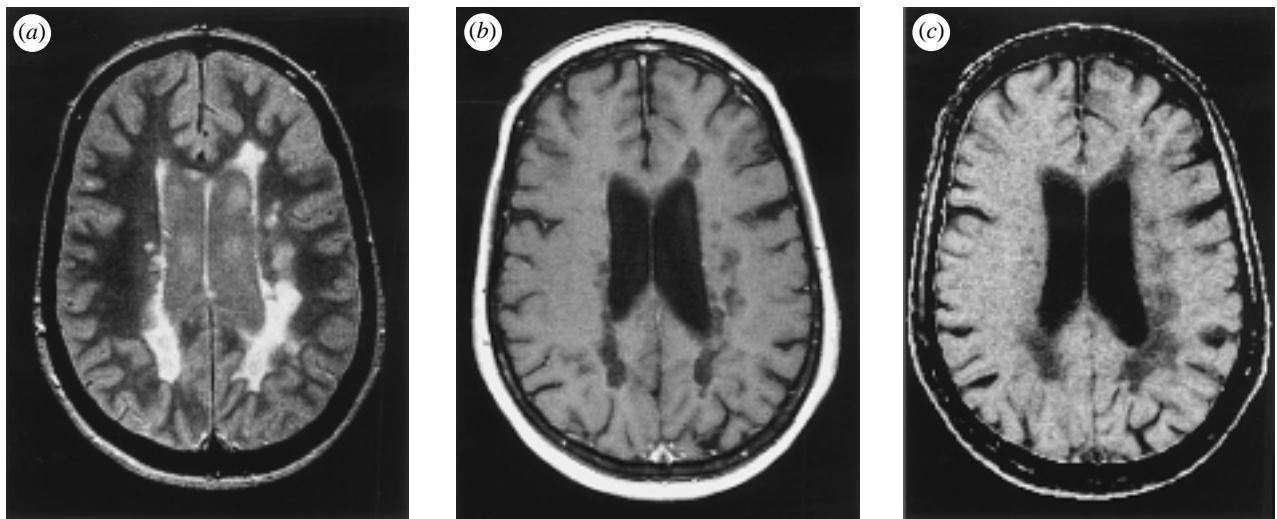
T2-weighted (a) and enhanced T1-weighted (b) MR images versus MT ratio (MTR) image (c) of an MS patient. Part of the abnormalities which are visible on the T2-weighted MR image (a) as increased signal intensity areas have low signal intensity (hypointense lesions or 'black holes') on the corresponding T1-weighted MR image (b). Note that the hypointense lesion load resembles the 'MTR lesion load', although more abnormalities are visible on the MTR image (c) than on the T1-weighted image, possibly due to a diffuse involvement of the brain matter surrounding the hypointense lesions.
